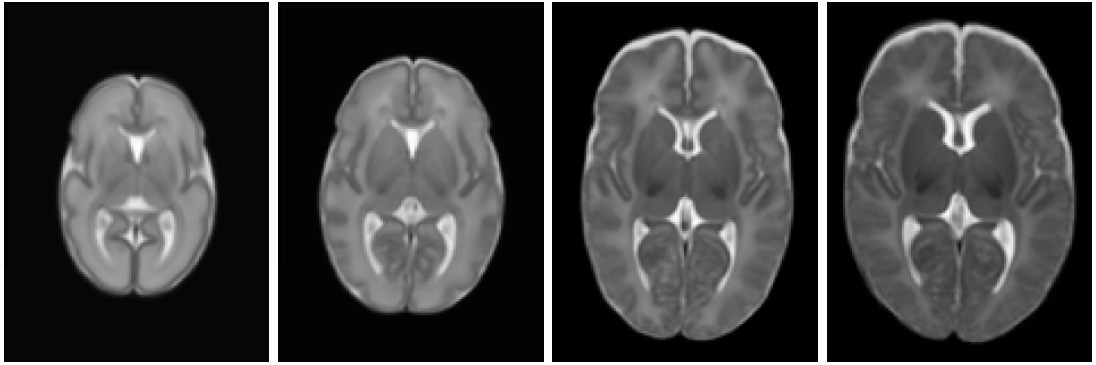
Representation of differences in terms of shape and size in neonatal T2 weighted MRI depending on the gestational age. Images are constructed from 204 premature infants [Serag et al., 2012]. From left to right: extremely preterm age (28w), preterm age (33w), term age (39w) and post term age (44w).
